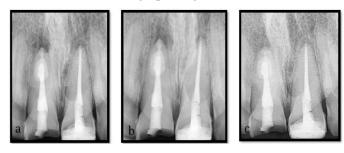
Follow-up radiograph of maxillary right central incisor (a) one-month post-operative; (b) three-month post-operative; (c) six-month post-operative. Note the periodic healing of periapical radiolucency
